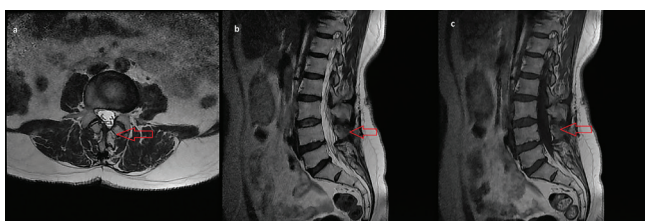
Postoperative 2nd month MRI of operated L4-5 disc herniation and repaired incidental durotomy. Laminectomy level on left L4-5 (a) (surgery level: red arrow).
